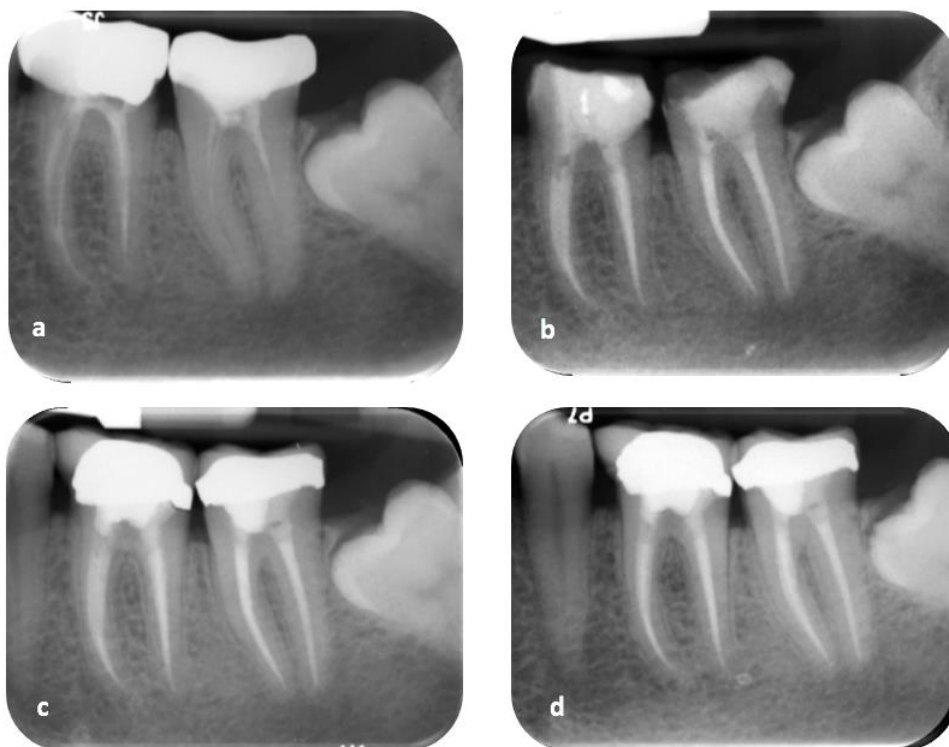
Review of teeth 36, 37 (a) Pre-operative radiograph (b) Postoperative radiograph (c) 1-year review (d) 2-year review, showing no apical pathology
